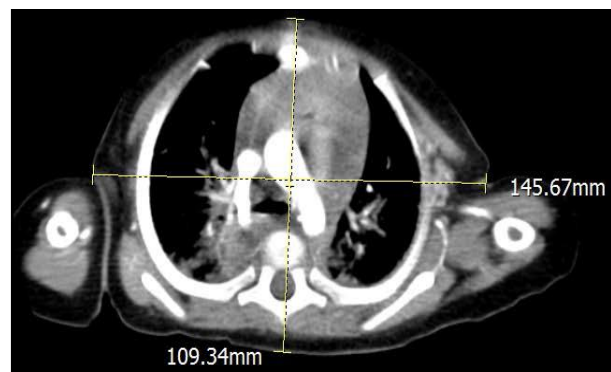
Axial slice of chest CT image, just before bifurcation of aorta, both horizontal and vertical yellow lines were used to measure the Lateral (LAT) and Antero-Posterior (AP) dimensions of the pediatric patient.
